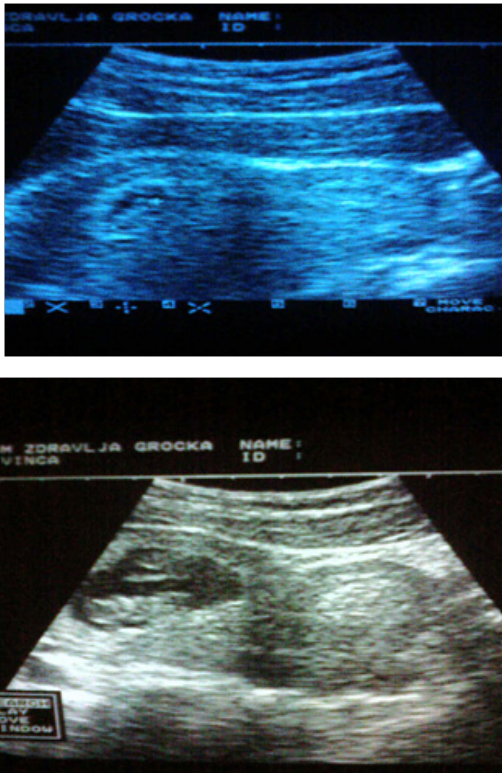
Patient G.J. 1988 age Ultrasound examination carried out 6 times. Spontaneously delivered a live male child 2600/50.
